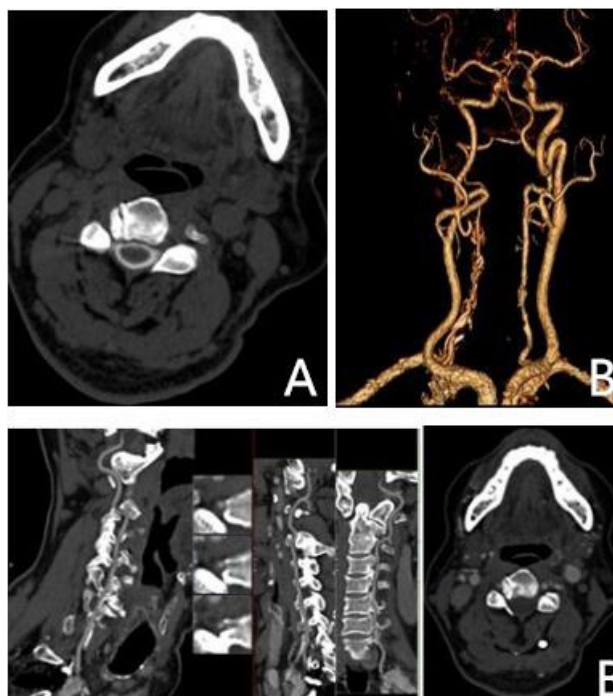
Preoperative CT Scan. Preoperative Axial Computer tomography images: (A): intervertebral foraminal stenosis at C3-4; (B): CTA of Right and left done shows no abnormal position of vertebral arteries.
